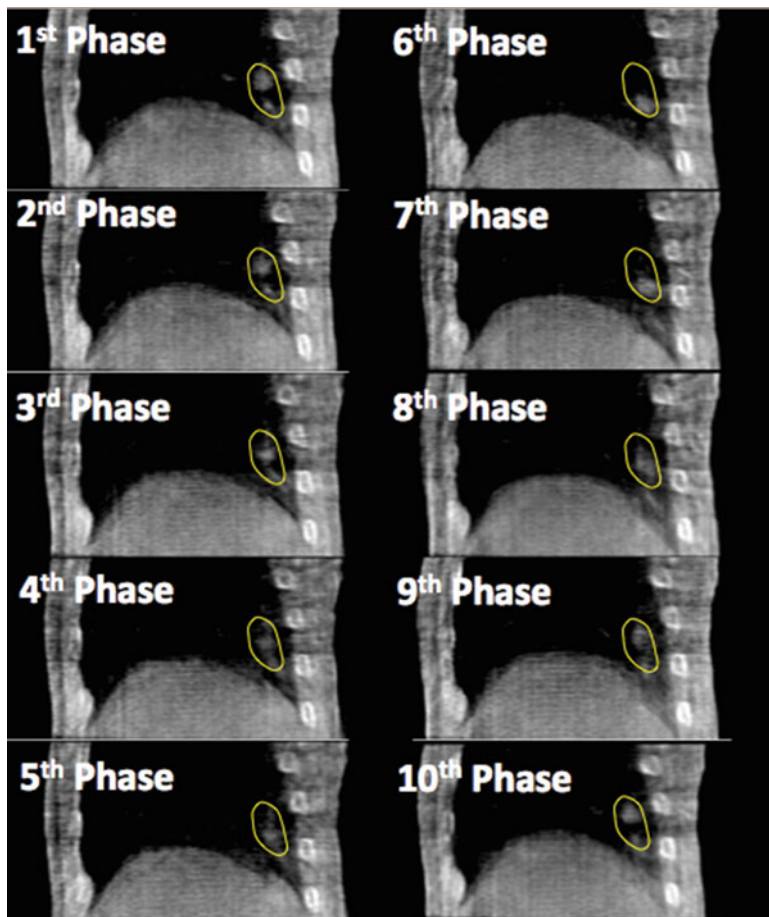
Example of the in-treatment 4D CBCT with 10-phase bins. The *yellow* means the PTV
